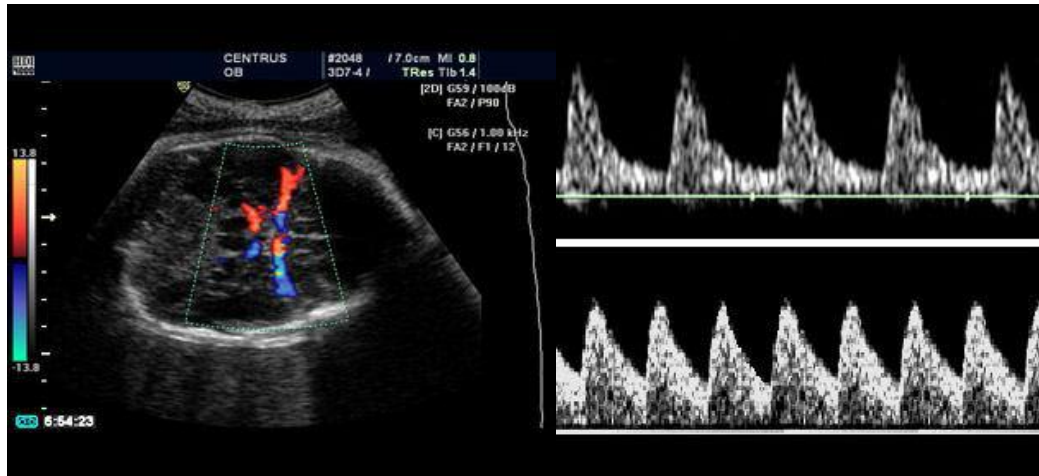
Color Doppler examination of the circle of Willis (left). Flow velocity waveforms from the middle cerebral artery in a normal fetus with low diastolic velocities (right, top) and in a growth-restricted fetus with high diastolic velocities (right, bottom). (Werner S et al 2011)
